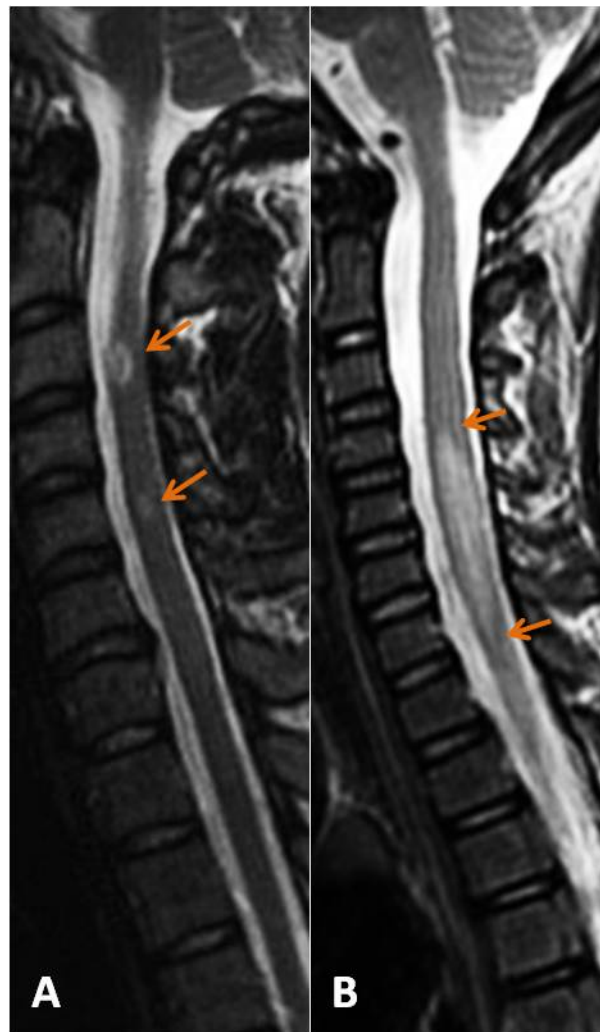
Sagittal T2-weighted FSE images of the spinal cord. Two children with MS demonstrating spinal cord involvement: (A) one child with two focal cervical T2-hyperintense lesions (arrows) and (B) one child with a cervical longitudinally-extensive lesion spanning four vertebral bodies (bounded by arrows) with associated spinal cord swelling.
